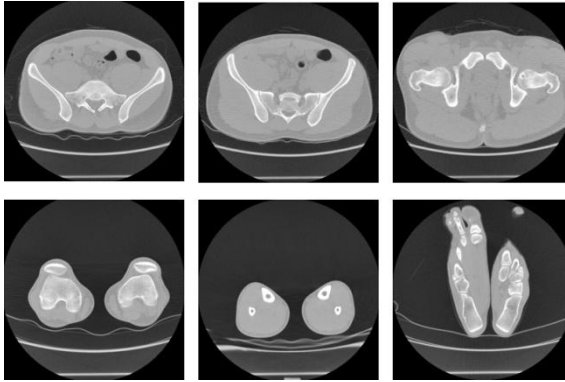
CT images of the lower-limb structures*
